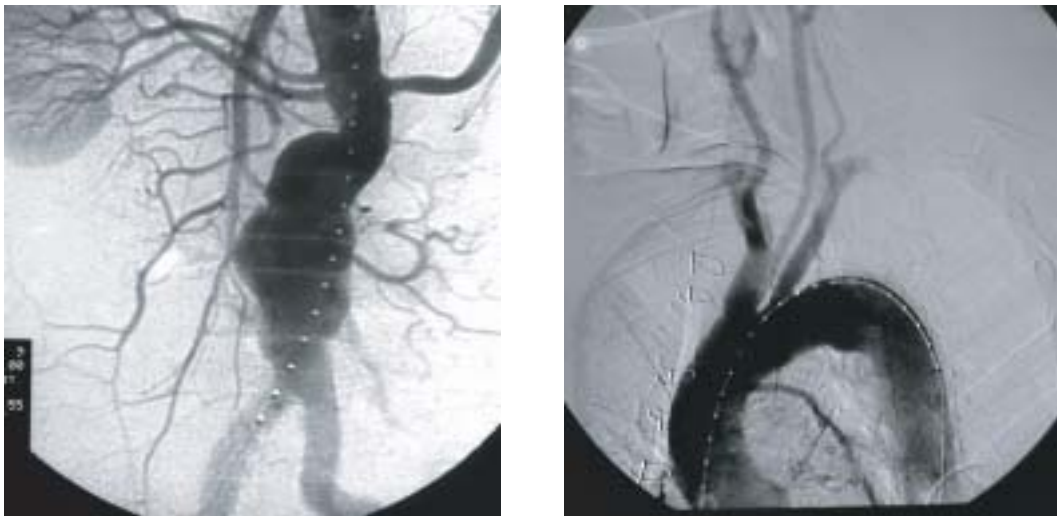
Left:* A X-ray Image of an AAA. *Right:* A X-ray Image of a TAA.
